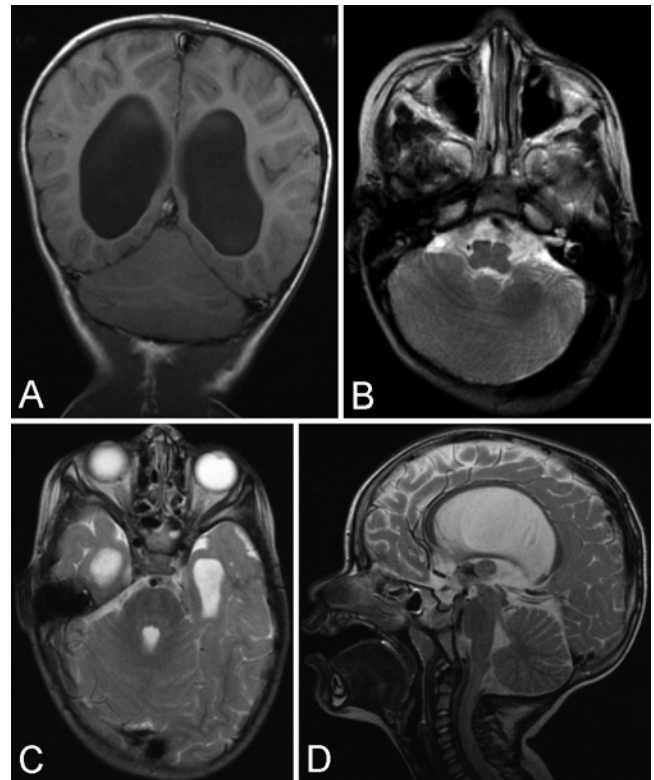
Case 3. A: Coronal T1-weighted image showing fused cerebellar hemispheres indicative of RS. Note continuity of cerebellar folia across the midline, without a clear cleavage plane separating the hemispheres. There is ventriculomegaly involving the lateral ventricles. B: Axial T2-weighted image showing fused cerebellar hemispheres lacking an intervening vermis, consistent with RS. C: Axial T2-weighted images demonstrating pointing of the posterior aspect of the fourth ventricle characteristic of RS. D: Sagittal T2-weighted image showing hydrocephalus and elevation of the superior aspect of the tectum, in keeping with aqueductal stenosis.
